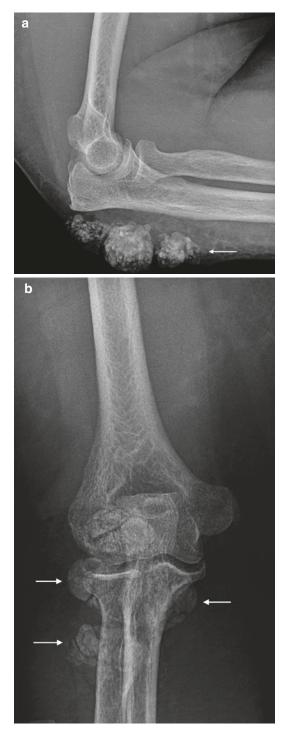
Tumoral calcinosis with dense calcification within enlarged olecranon bursa. (a) Lateral and (b) AP radiographs
